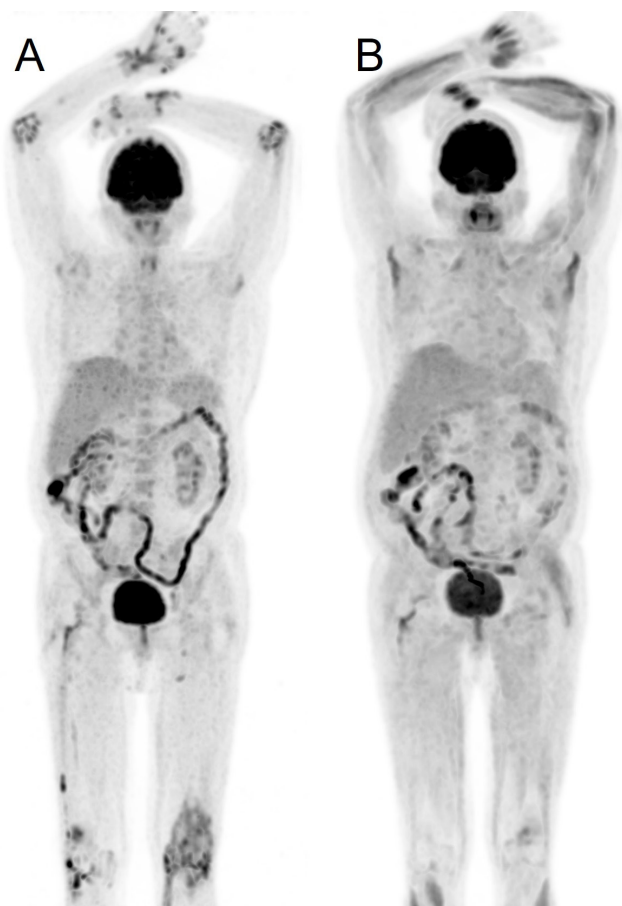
Representative image of joint inflammation visualised by ^{18}F -fluorodeoxyglucose-PET/CT at baseline and after tofacitinib treatment in a patient with RA. (A) Baseline PET/CT MIP image demonstrates intense synovial activity in multiple joints, including wrists, small hand joints, elbows and knees bilaterally. (A) Baseline PET/CT MIP image demonstrates intense synovial activity in multiple joints including wrists, small hand joints, elbows and knees bilaterally. (B) There is marked reduction of FDG uptake after 12 months of treatment. FDG, ^{18}F -fluorodeoxyglucose; MIP, multiple intensity projection; PET, positron emission tomography; RA, rheumatoid arthritis.
